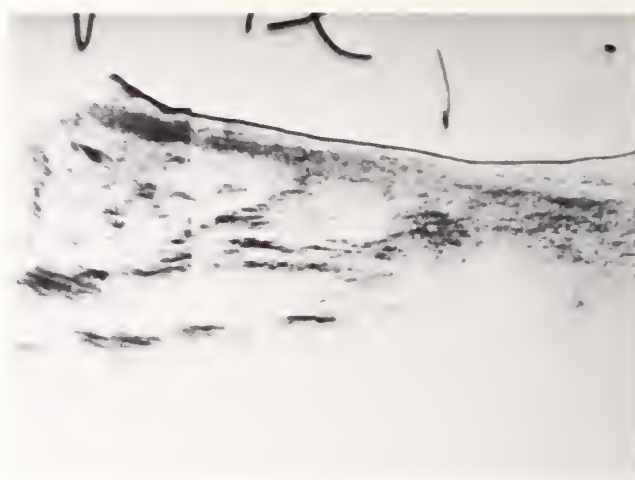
The large pancreatic mass is demonstrated on this sagittal view of the sonography study.
